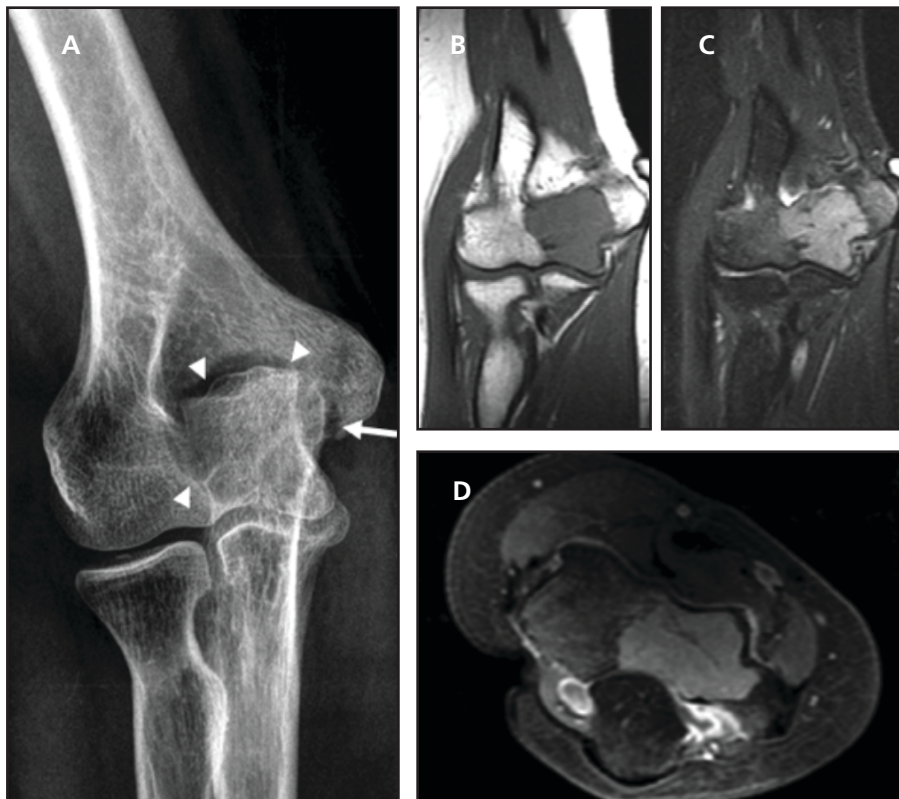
Frontal radiograph of the right elbow (A) demonstrates a geographic lucent lesion in the epiphysis of the distal right humerus (arrowheads), extending to the trochlear articular surface (arrow). There is no periosteal reaction, cortical destruction, or evidence of soft tissue component. Coronal T1 (B) and short tau inversion recovery (STIR) (C) MR images confirm the findings on the radiograph. The lesion demonstrates intermediate T1 and intermediate high T2 signal. The extent of the lesion is limited to the epiphysis. Axial fat-suppressed T1 postcontrast image (D) demonstrates mild diffuse homogeneous enhancement.
